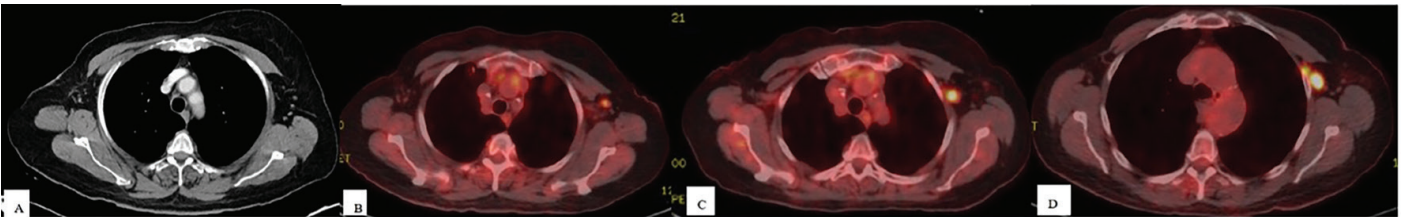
A) In a patient with a history of right mastectomy, reactive lymph nodes were observed in the left axilla in 2020. B) In 2022, after vaccination, a lymph node with an SUV_{max} of 3.6 was detected on 18F-FDG PET/CT. FNAB was performed, and the result was benign. C) In February 2023, FNAB was repeated for a lymph node with an SUV_{max} of 8.6. The result was benign. D) In September 2023, an increase in both size and number of lymph nodes was observed, with an SUV_{max} of 8.4. A tru-cut biopsy was performed and interpreted as reactive growth
